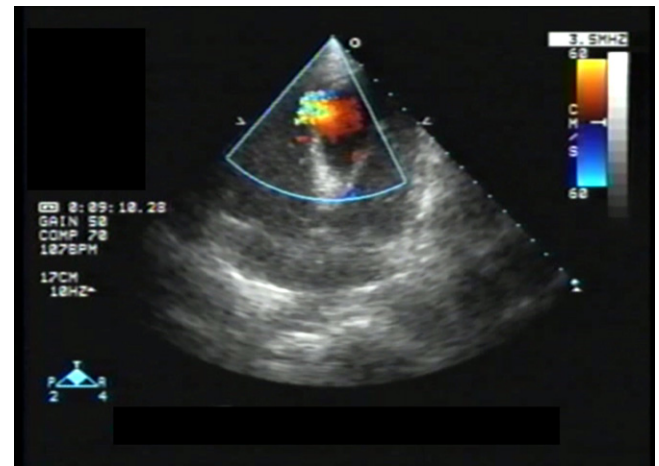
Doppler color flow mapping on transthoracic echocardiography showing a septic perforation of the interventricular septum (0.8 cm in diameter) with a measured pulmonary-to-systemic (Qp:Qs) flow ratio of 2.1:1.
